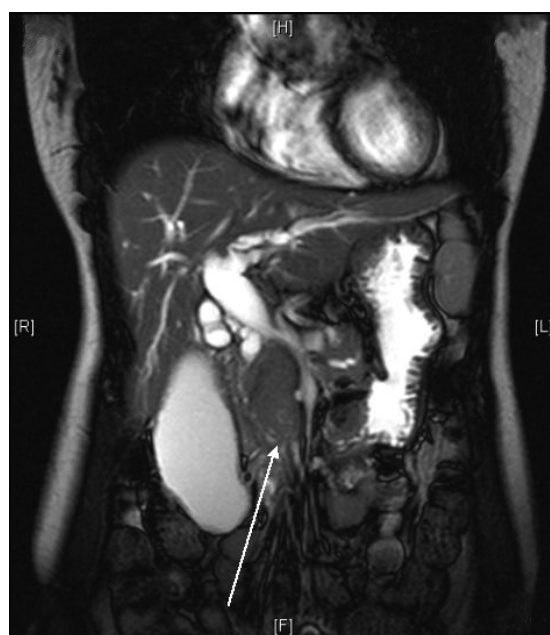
Coronal fat-suppressed T2-W MR image of the abdomen shows a tumour in the head and uncinate process (arrow) causing compression and displacement with possible invasion of the portal vein.
